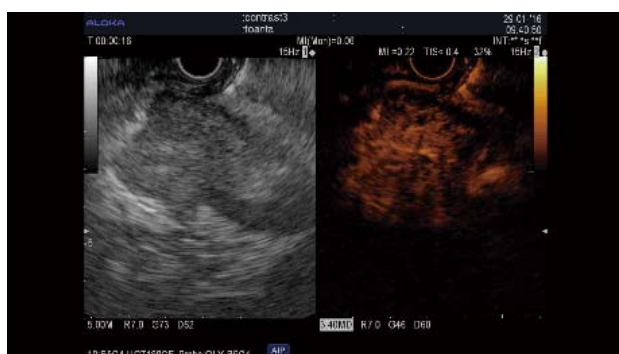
Contrast-enhanced harmonics-endoscopic ultrasound of a neuroendocrine pancreatic tumor. Standard endoscopic ultrasound image (left) of a hypoechoic, well-delineated lesion of the head of the pancreas. The contrast image (right) shows a hyperenhanced lesion that is suggestive of a neuroendocrine tumor, as later proved by fine needle aspiration.
